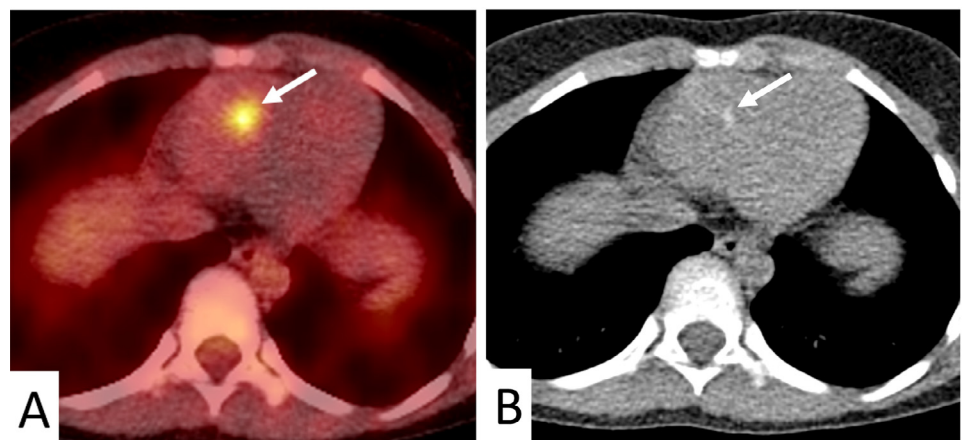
Baseline ^{18}F -FDG PET/CT. Fused axial PET/CT image (A) shows focally increased glucose metabolism in the right cardiac cavity (arrow). In the same position, a subtle spot of calcification is visible in the co-registered low dose CT (B). ^{18}F -FDG PET/CT, Fluorine-18-fluorodeoxy-glucose positron emission tomography/computed tomography.
